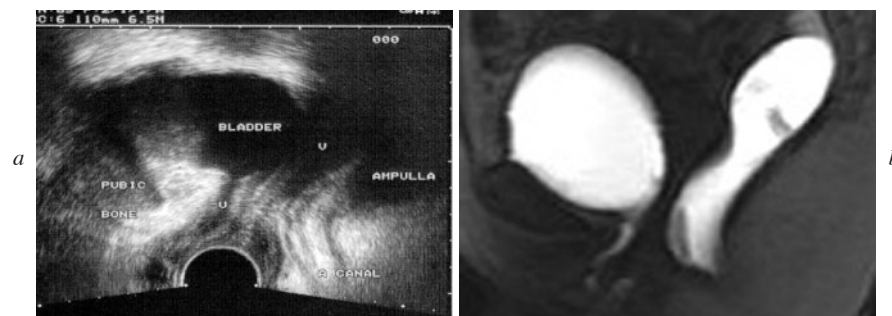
Standardized documentation of female perineal sonogram. (a) Longitudinal scan: with the transducer displayed at the bottom of the screen, caudal of the patient is seen at the lower edge and cranial at the top; the left side of the scan is ventral and the right side is dorsal. The same orientation is displayed in this standard MRI sagittal scan of female pelvis (b).
